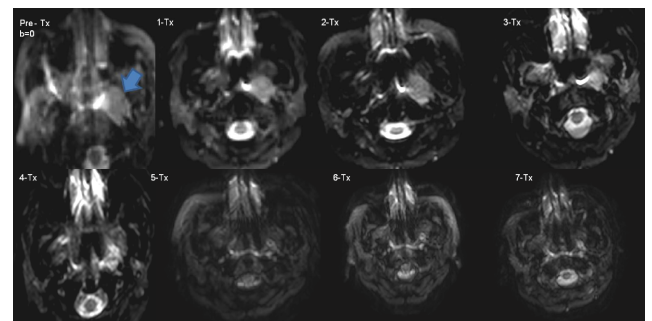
Weekly IVIM DW-MRI data (b=0) from a nasopharyngeal cancer patient (Patient #1 in Table 1) undergoing chemoradiation therapy (The blue arrow delineates the location of the tumor).
